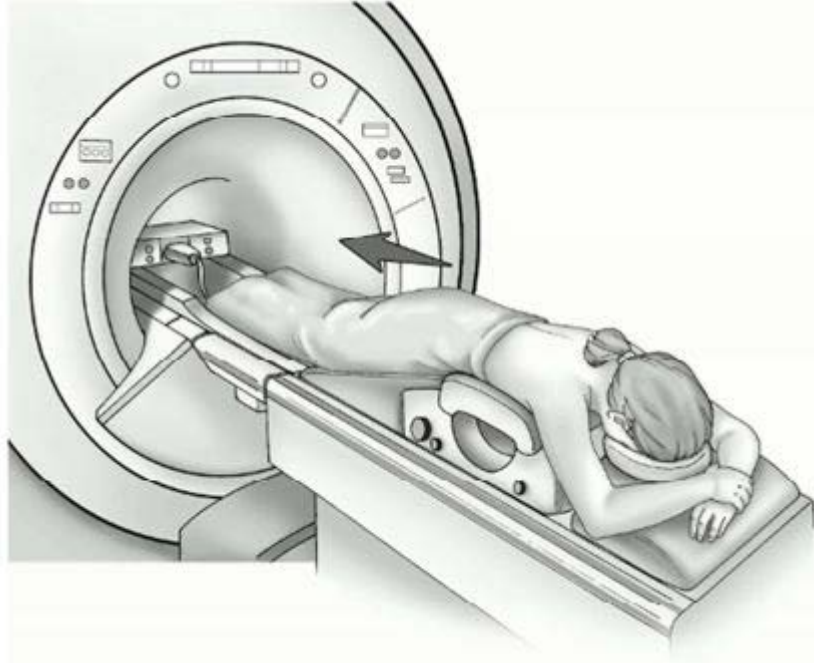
Breast MRI (ACS, 2015).
